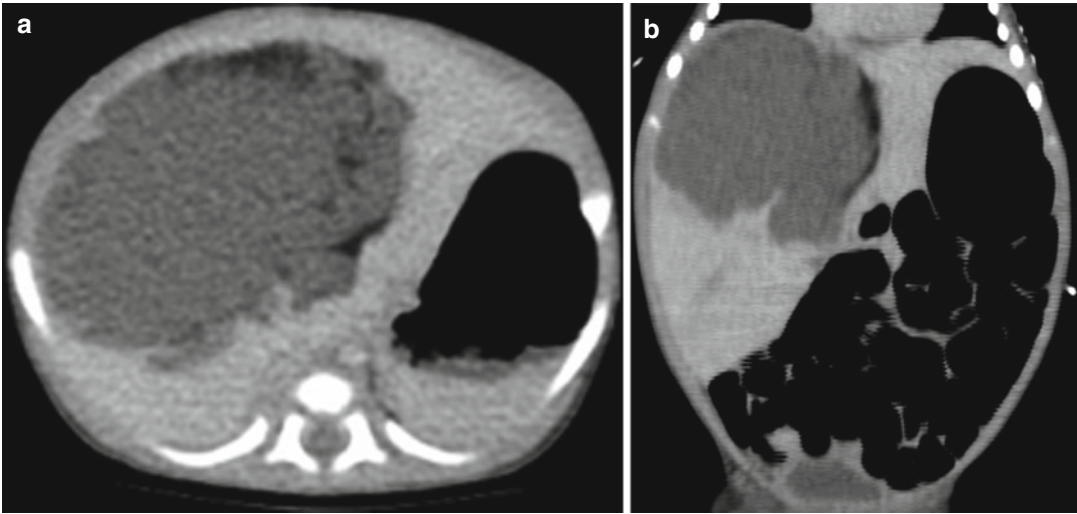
(a, b) CT imaging of the liver of a neonatal with voluminous abscess (axial and coronal MPR reconstruction)
